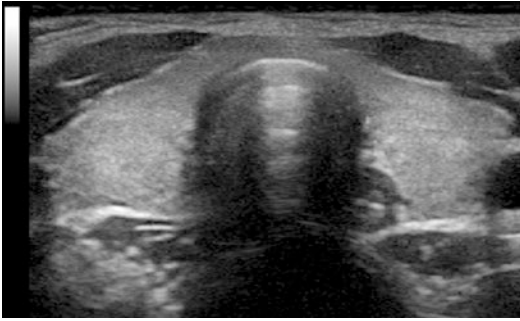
Acoustic shadowing. Due to the extreme reflection from the tissue-air interface of the trachea, no image is seen behind the trachea on an anterior ultrasound
